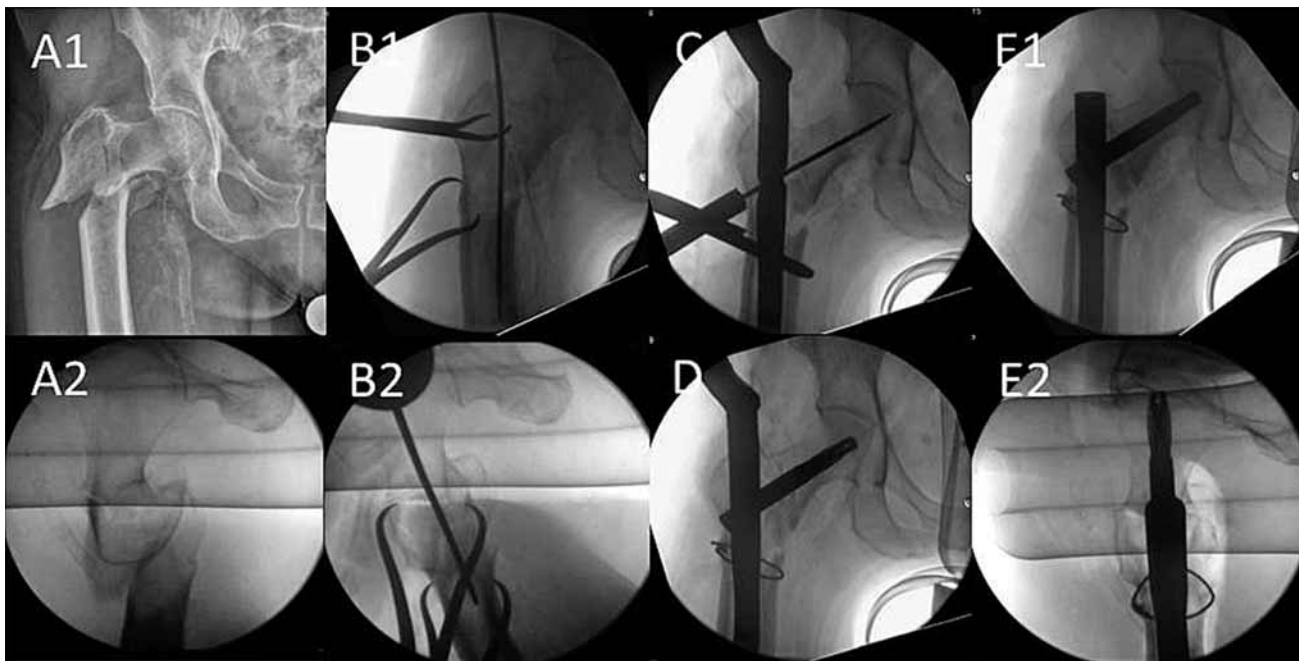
A1 and A2 –preoperative (AP) and intraoperative (lateral) view. Isolated AO 31-A3 fracture. A limited open approach was performed from the start to address the lateral spike of the proximal fragment. Preoperative planning included a cable cerclage to augment the nail osteosynthesis in this unstable situation. B1 and B2 – AP and lateral view. The fracture was reduced with two pointed reduction clamps before insertion of the guide wire. Note the rather medial insertion point of the guide wire to avoid later varus malalignment. C – AP view. Application of a collinear reduction clamp to maintain the reduction during insertion of the long PFNA and blade. D – AP view. The traction was released to close the remaining fracture gap on the medial aspect of the femur before the cable was finally tightened. E1 and E2 – AP and lateral view. Final X-rays after insertion of the dynamic distal locking screw demonstrated an adequate fracture reduction and correct position of the implants. Partial weight bearing for six weeks was recommended.
